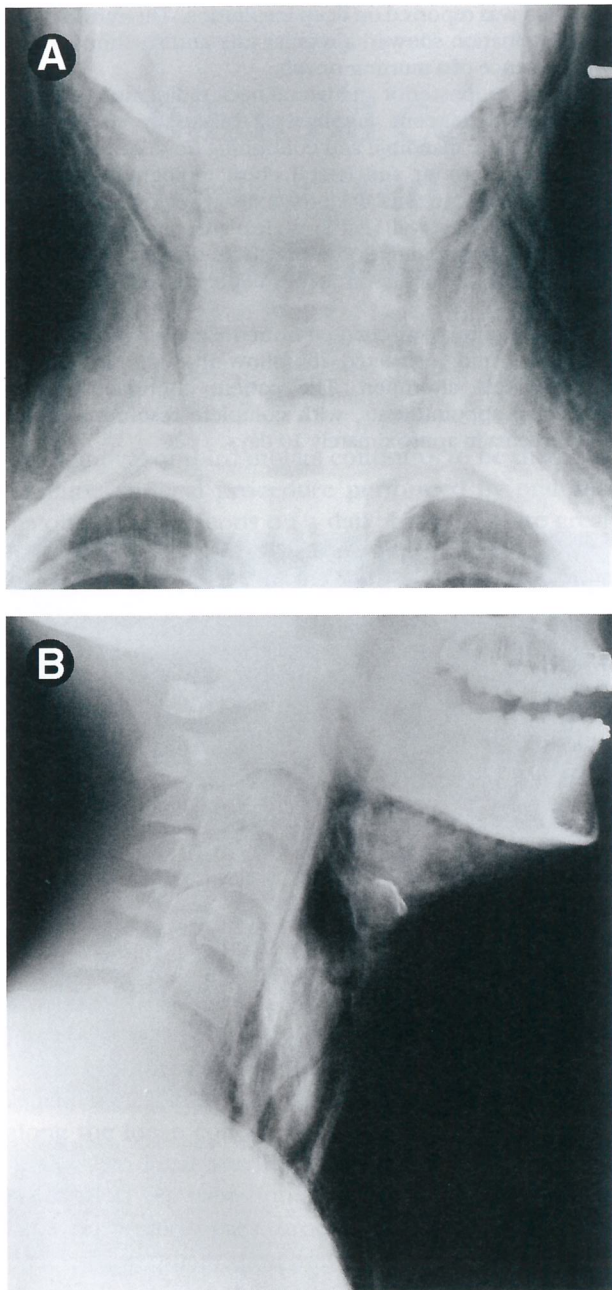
Subcutaneous emphysema in the cervical region seen on the A, frontal and B, lateral radiographs.
